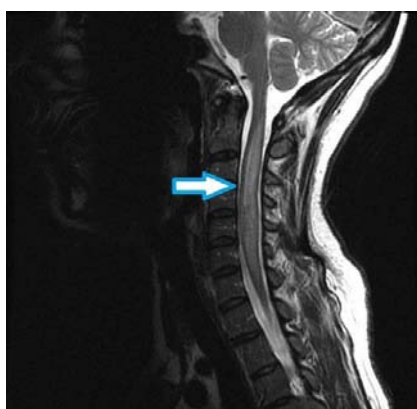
Figure 1 is a T2-weighted sagittal image of the cervical spine. The arrow shows an expansile hyperintense lesion in the cervical cord. The lesion extends from C2 through C7.
